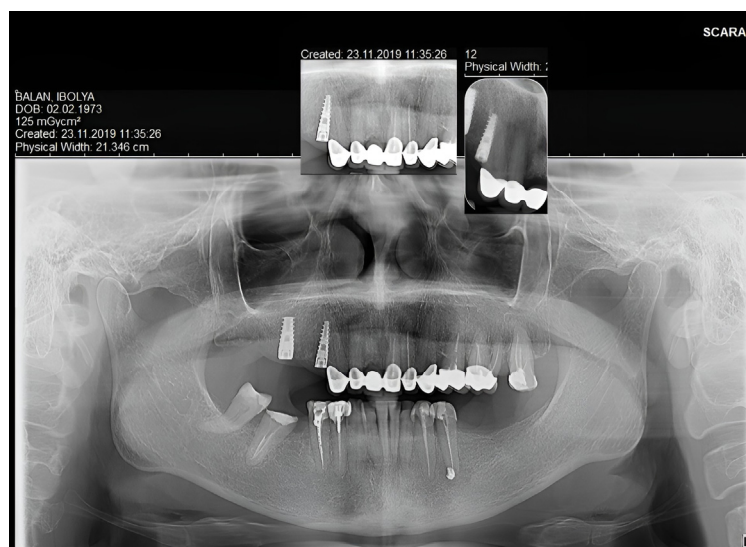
Panoramic X-ray with the osseointegrated implants and the maxillary prosthodontic rehabilitation on the natural teeth.
